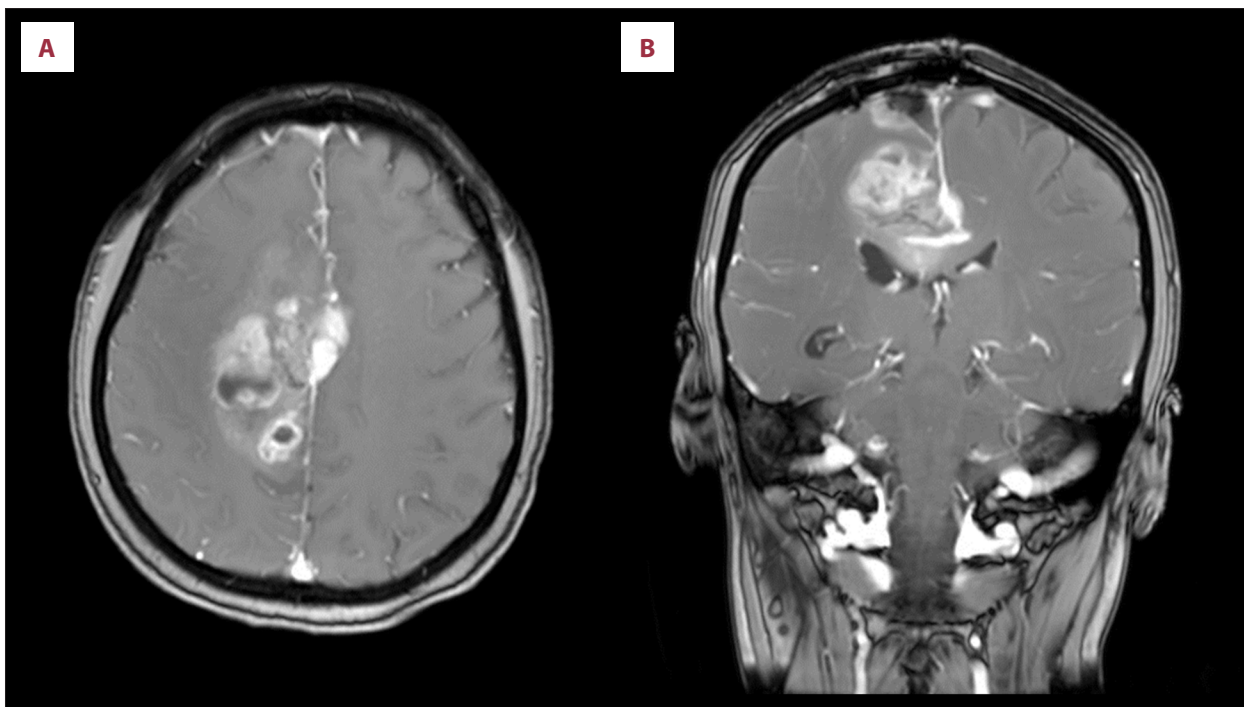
Contrast-enhancing solid and cystic mass seen on axial (A) and coronal (B) views of MRI, along with leptomeningeal involvement.
